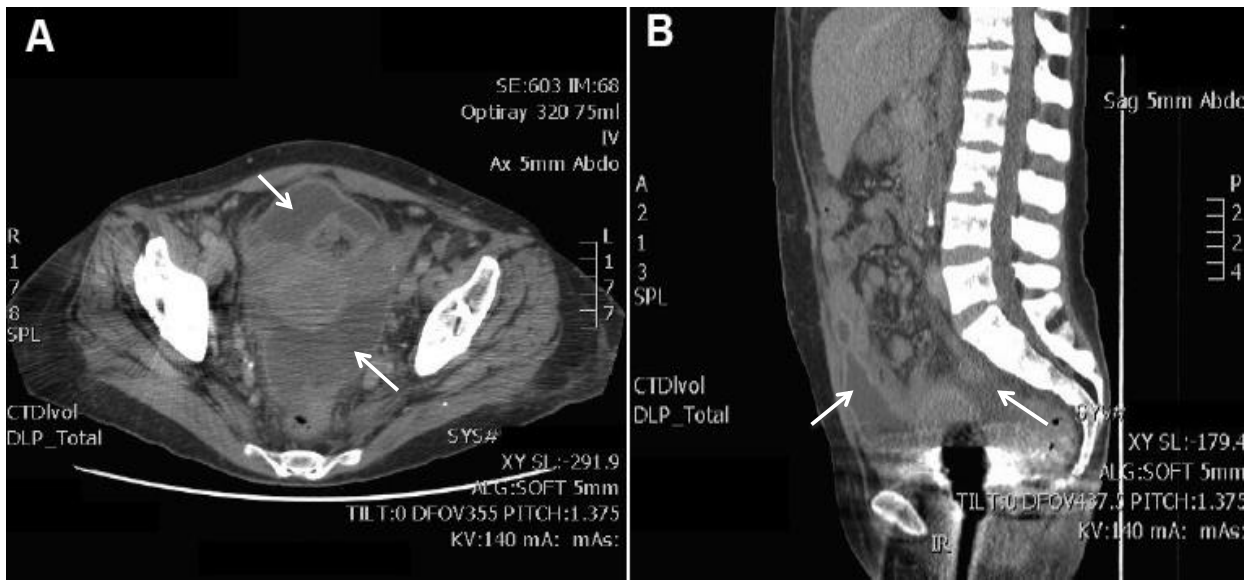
Computed tomography scans demonstrating persistent intra-abdominal collections (arrows). Axial section (A), sagittal section (B).
